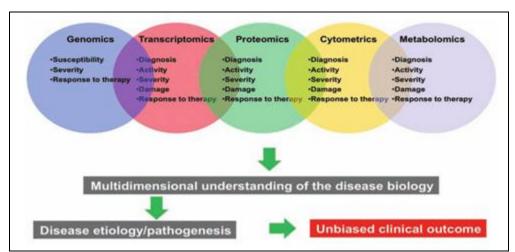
SHOWING A MULTI-OMICS METHOD FOR FINDING AND CONFIRMING BIOMARKERS TO EXAMINE DIFFERENT ASPECTS OF THE BIOLOGY OF DISEASE. TO IDENTIFY THE BEST PREDICTIVE BIOMARKERS ACROSS DNA, RNA, PROTEIN, PHENOTYPIC, AND METABOLITE DOMAINS, A COMPREHENSIVE BIOMARKER DISCOVERY, DEVELOPMENT, AND VALIDATION EFFORT MUST INTEGRATE SEVERAL 'OMICS' TECHNOLOGIES, DATA TYPES, DATABASES, BIOINFORMATICS, AND BIOSTATICS <sup>25</sup>
